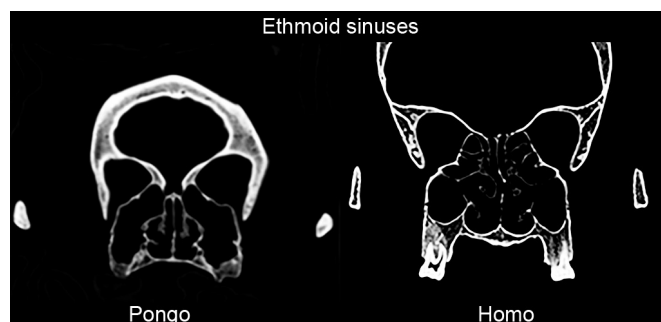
Computed tomographic scan, coronal view, of skulls of Pongo (orangutan), left frame, and Homo (human), right frame, showing a lack of ethmoid sinuses in the orangutan compared with prominent ethmoid sinuses (arrow) in the human.
